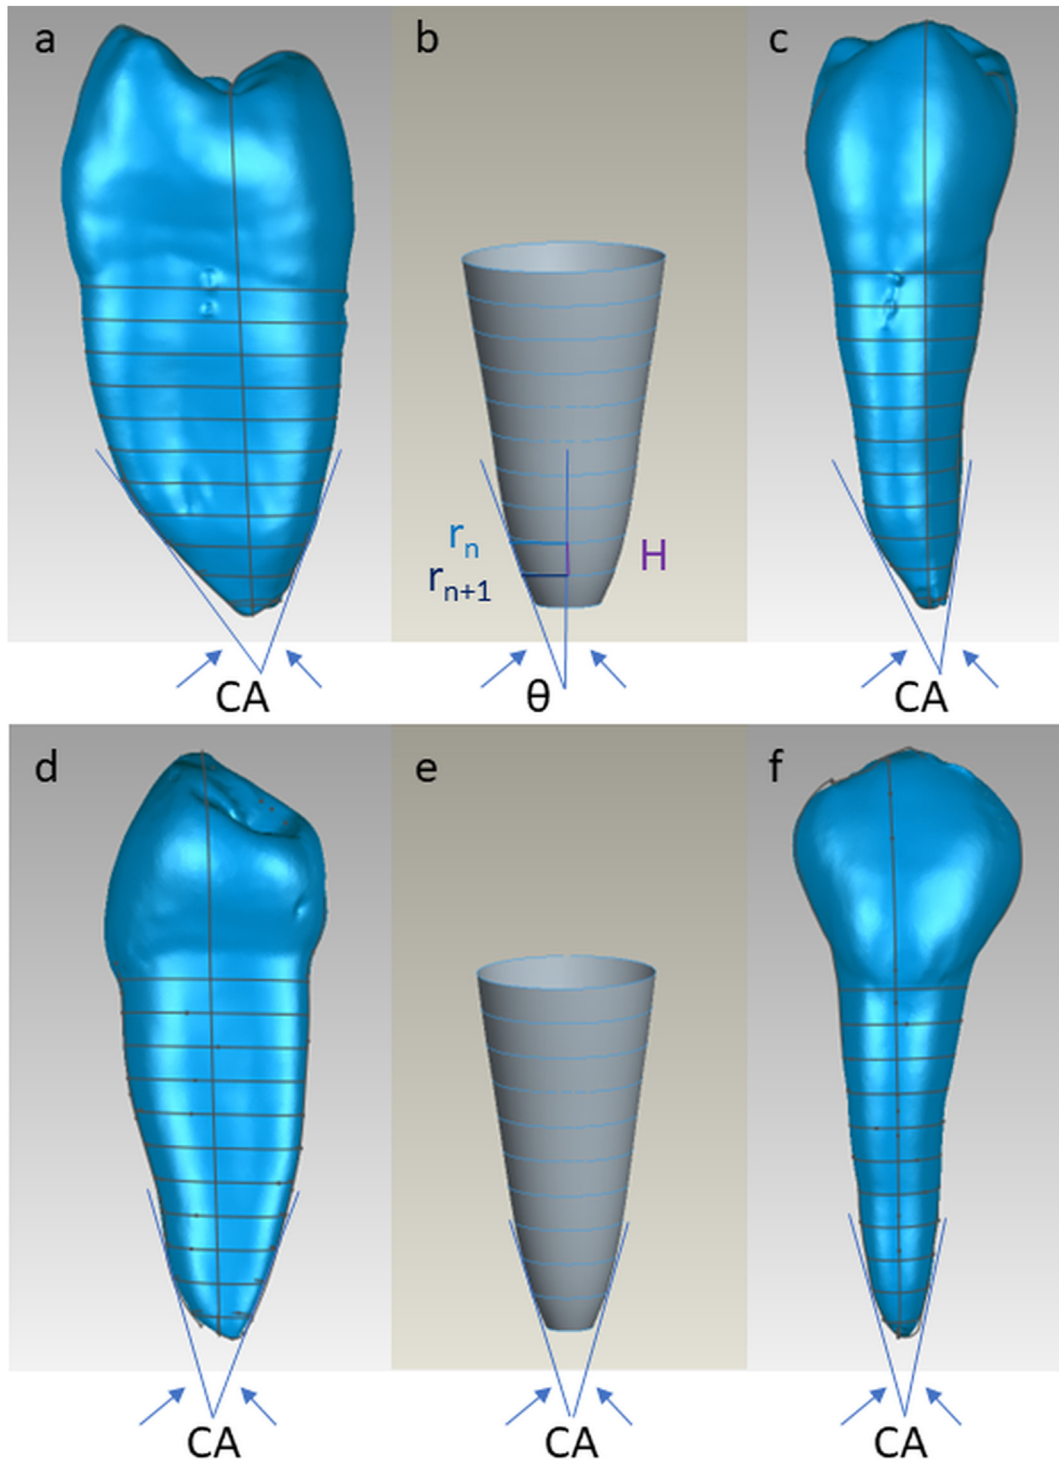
Three-dimensional reconstructions from microcomputed tomography images. a–c: Maxillary premolars; d–f: Mandibular premolars. a & d: Convergent angles (CAs) from the buccolingual measurement. b & e: Transformation of the natural root into a biomimetic dental implant (BDI). r_n : radius of the cross-section at the examined level. r_{n+1} : radius at the next level apical to r_n . H : length of each adjacent slice. θ : angle formed by the long axis and one side of the BDI. c & f: CAs from the mesiodistal measurement.
